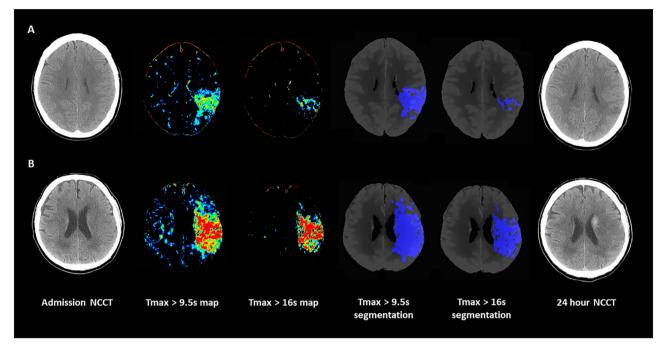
T_{max} volumes in 2 patients with AIS and anterior circulation large vessel occlusion. Panel A: NCCT at admission, color coded CTP T_{max} map with scale set at 9.6 to 25 seconds, Color coded CTP T_{max} map with scale set at 16.1 to 25 seconds, $T_{max} > 9.5$ seconds volume automatically segmented on CTP averaged images, $T_{max} > 16$ seconds volume automatically segmented on CTP averaged images, $T_{max} > 16$ seconds volume automatically segmented on CTP averaged images and NCCT at 24 hours in a 48 year-old patient with AIS and ischemic lesion in left MCA territory who presented the following T_{max} parameters: critically hypoperfused tissue = 39.5 ml; core volume = 8.7 ml; penumbra volume = 30.8 ml; and mismatch ratio = 4.5. FIV was 7.2 ml and mRS at 3 months was 0. Panel B: NCCT at admission, color coded CTP T_{max} map with scale set at 9.6 to 25 seconds, Color coded CTP T_{max} map with scale set at 16.1 to 25 seconds, $T_{max} > 9.5$ seconds volume automatically segmented on CTP averaged images, $T_{max} = 16$ seconds volume automatically segmented on CTP averaged images, $T_{max} = 16$ seconds volume automatically segmented on CTP averaged images, $T_{max} = 16$ seconds volume automatically segmented on CTP averaged images and NCCT at 24 hours with hemorrhagic transformation in a 67 year old patient with AIS and ischemic lesion in left MCA territory who presented the following T_{max} parameters: critically hypoperfused tissue = 158.0 ml; core volume = 87.4 ml; penumbra volume = 70.6 ml; mismatch ratio = 1.8. FIV was 131.2 ml and mRS at 3 months was 4. AIS = acute ischemic stroke; CTP = computed tomography perfusion; FIV = final infarct volume; MCA = middle cerebral artery; mRS = modified Rankin Scale; NCCT = non-contrast computed tomography; $T_{max} =$ time to maximum concentration.
